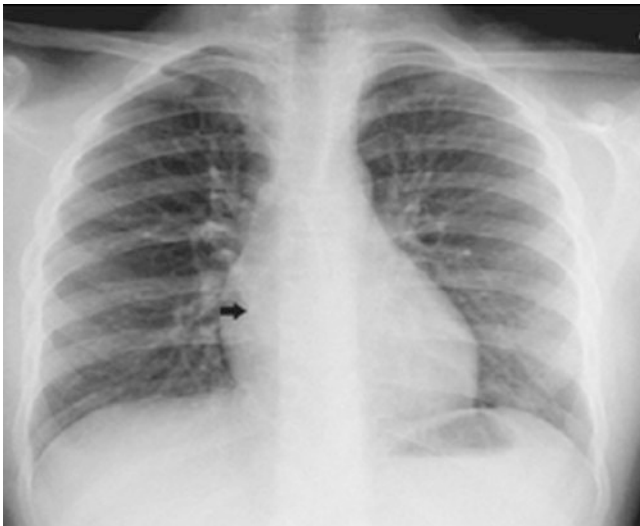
Normal PA radiograph in a 10-year-old showing the normal left atrial shadow (arrow)
